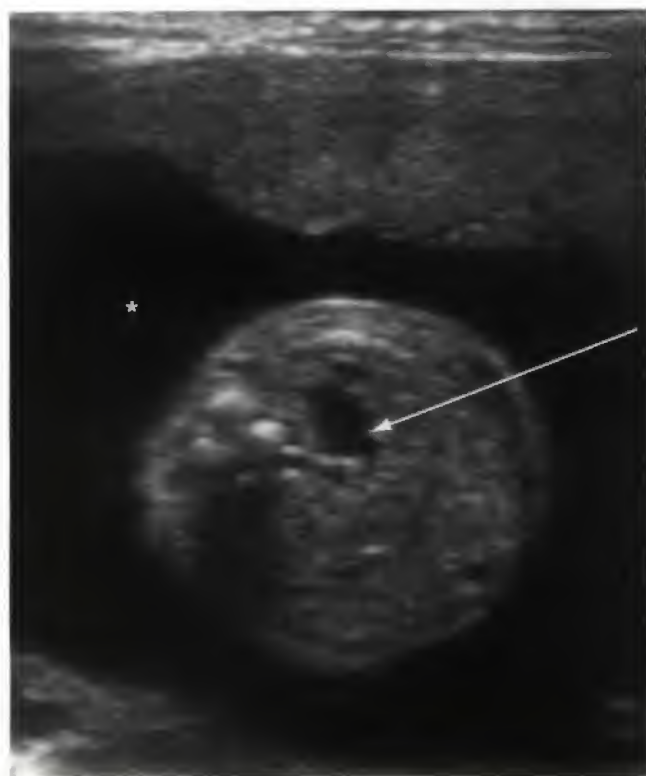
Sonogram of a patient with esophageal atresia and polyhydramnios. Absence of the fetal stomach (arrow) and increased amniotic fluid (asterisk) are seen.
